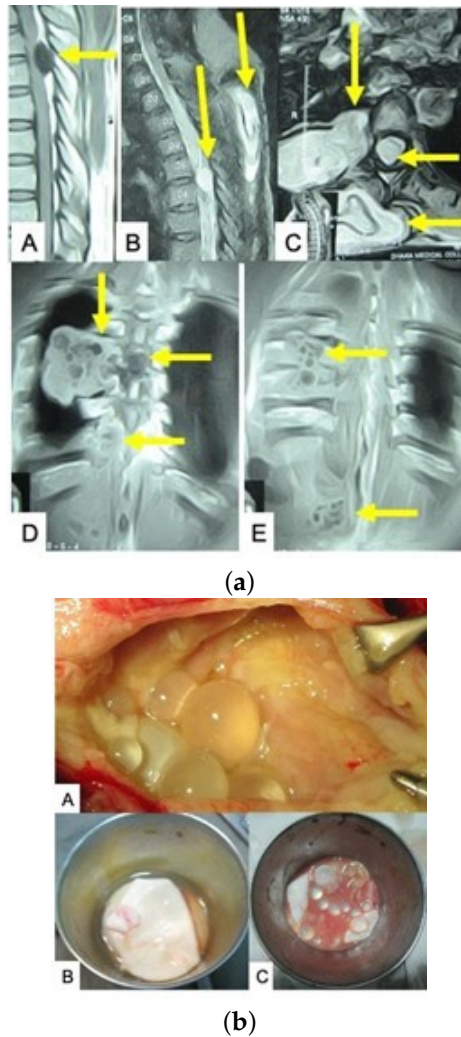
(a) MRI of dorsal spine (sagittal sections) showing spinal hydatid cyst causing cord compression (A,B); MRI of dorsal spine (axial section) showing spinal, mediastinal, and intramuscular hydatid cyst (marked with an arrow) (C); MRI of chest and upper abdomen (coronal section) showing hydatid cysts in mediastinum and liver (D,E). (b) Intraoperative pictures of patient in (a). Daughter cysts in intramuscular hydatid cyst (A); hydatid cysts after removal (B,C). Source: Figure by authors.
